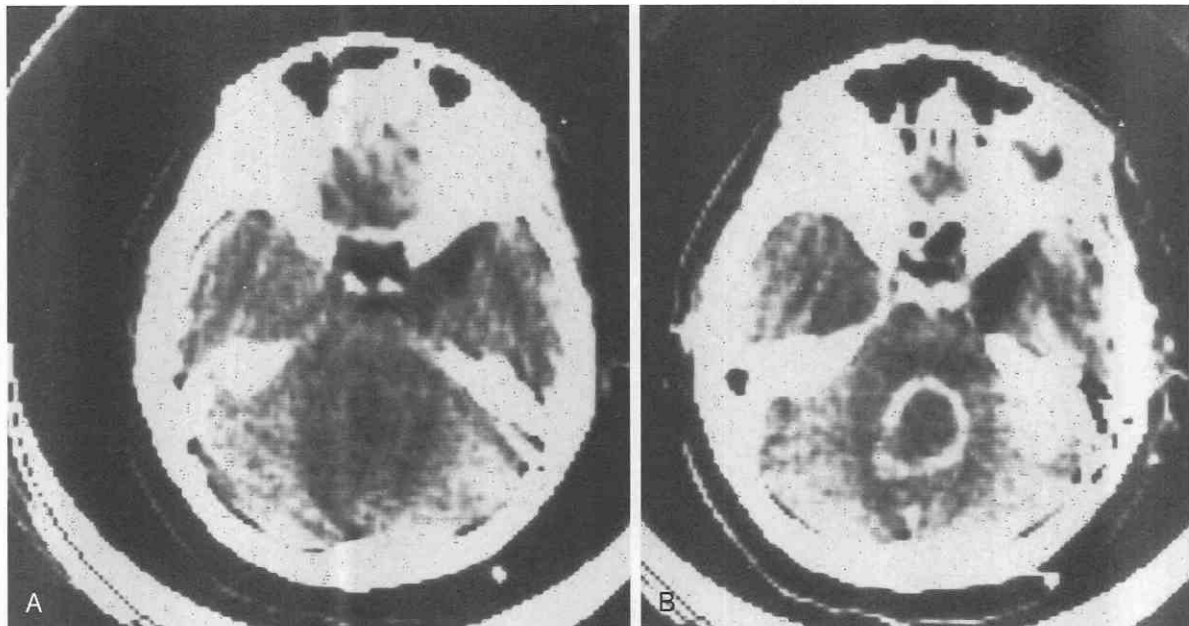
Enhancing intraventricular cysticercosis cyst. *A*, Noncontrast CT scan shows a low-density area in the region of the fourth ventricle. The fourth ventricle is obliterated. *B*, Contrast CT scan demonstrates a ringlike enhancement. (From Zee C, et al: Unusual neuroradiological feature of intracranial cysticercosis. *Radiology* 137:397-407, 1980.)
